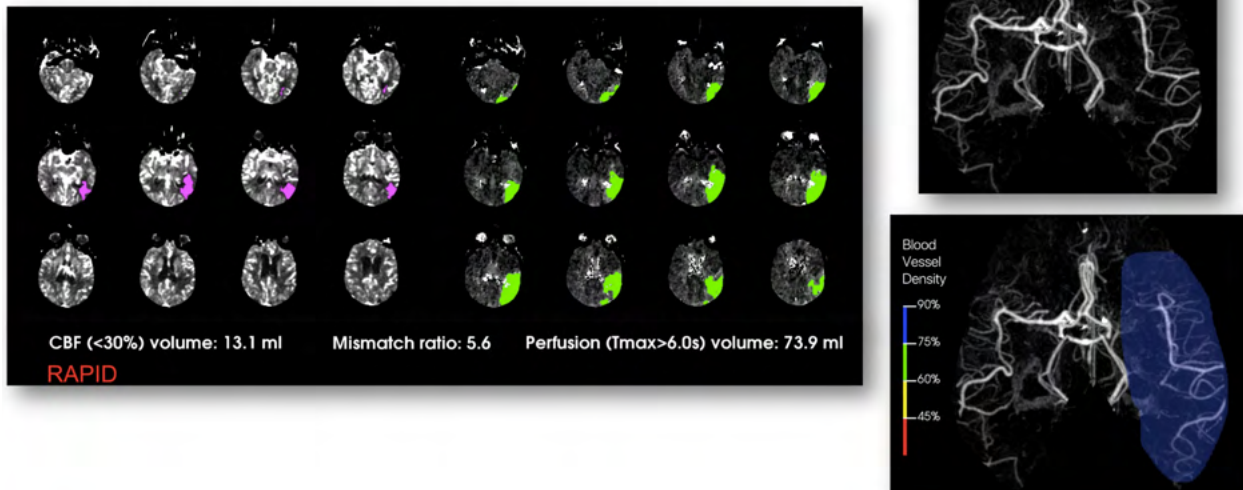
Computerised Tomography (CT) and Computed Tomography Angiography (CTA) images of a middle cerebral artery (MCA) stroke.
